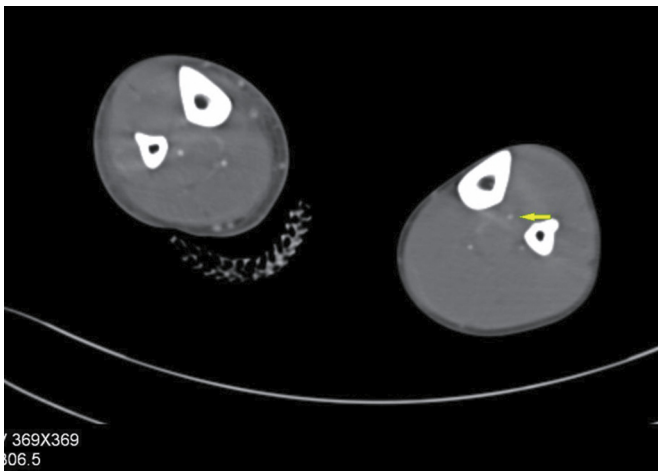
Coronal CTA shows occlusion of left limb tibial artery, the yellow arrow displays left tibial artery, comparing with the right one.
